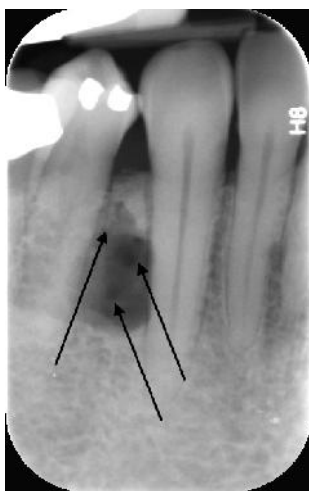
Periapical radiograph showing multilocular appearance of radiolucent lesion (arrows).
